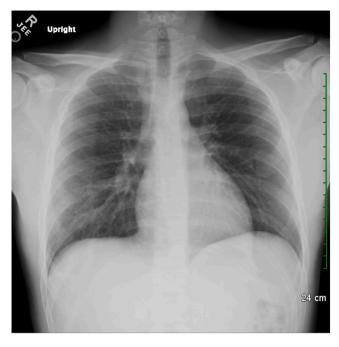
Chest x-ray. Subtle opacities in the right middle lobe.
